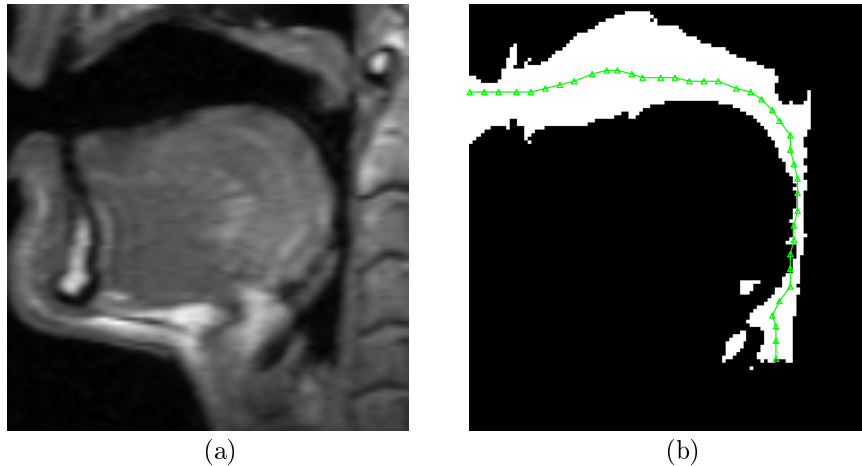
Evaluation of the functional anatomy of the oro-pharyngeal cavity during phonation using MRI: (a) Midsagittal MRI section of the vocal tract. (b) Segmented vocal tract with nonlinear principal component as defined by a 1D-SOM.
